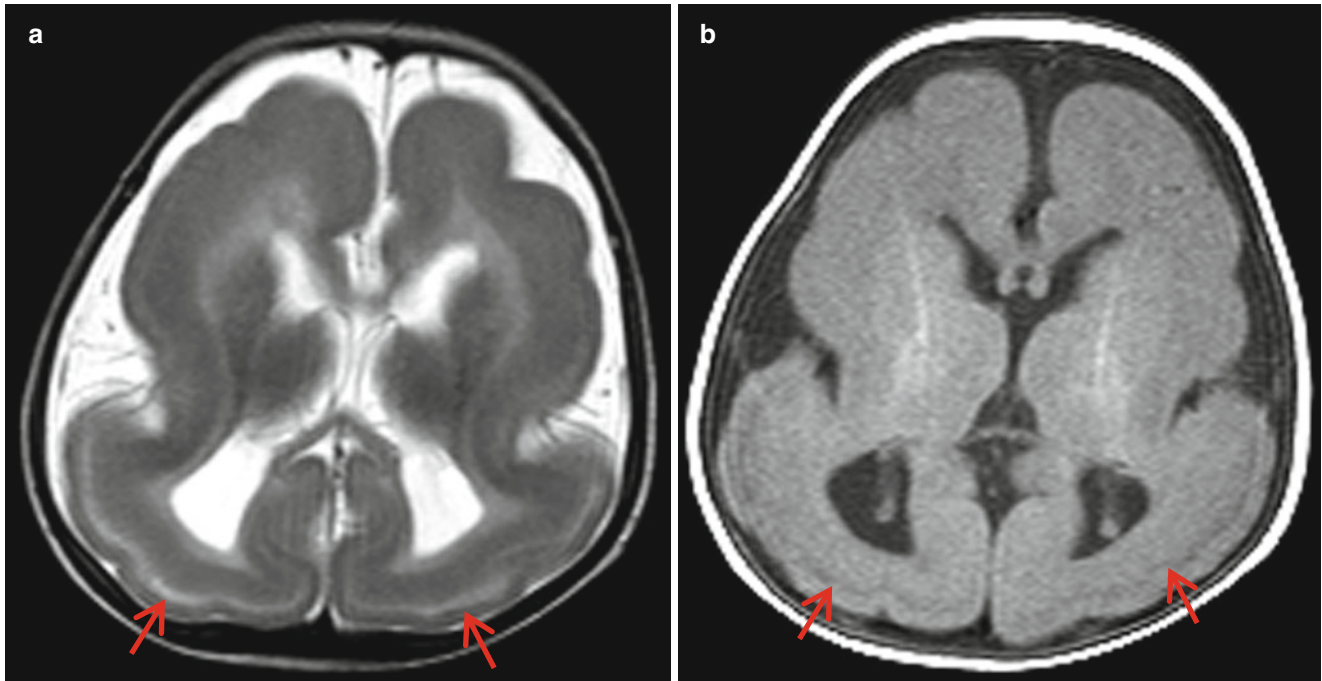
Lissencephaly. (a) Axial T2-weighted image shows nearly smooth brain with shallow Sylvian fissure. The cortex is abnormally thick and outer linear band of high signal intensity (*arrows*) represents
